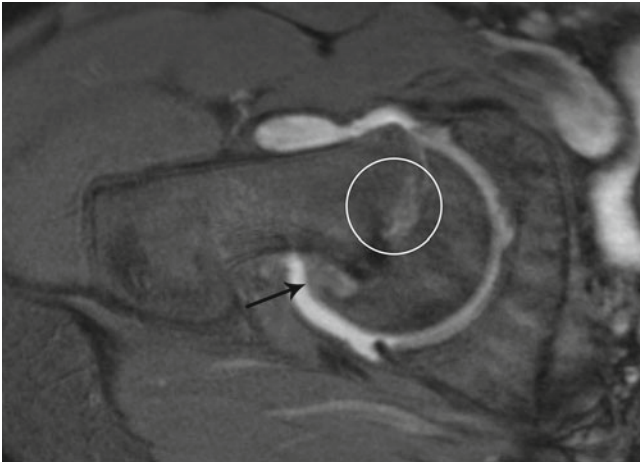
Radial T2 MRI of an acutely unstable slip. Callus is visible posteriorly (*arrow*) and bone marrow edema is present around the physis (*circle*). A closed reduction of the epiphysis would stretch the retinacular vessels over the posterior callus, endangering the blood supply to the femoral head
